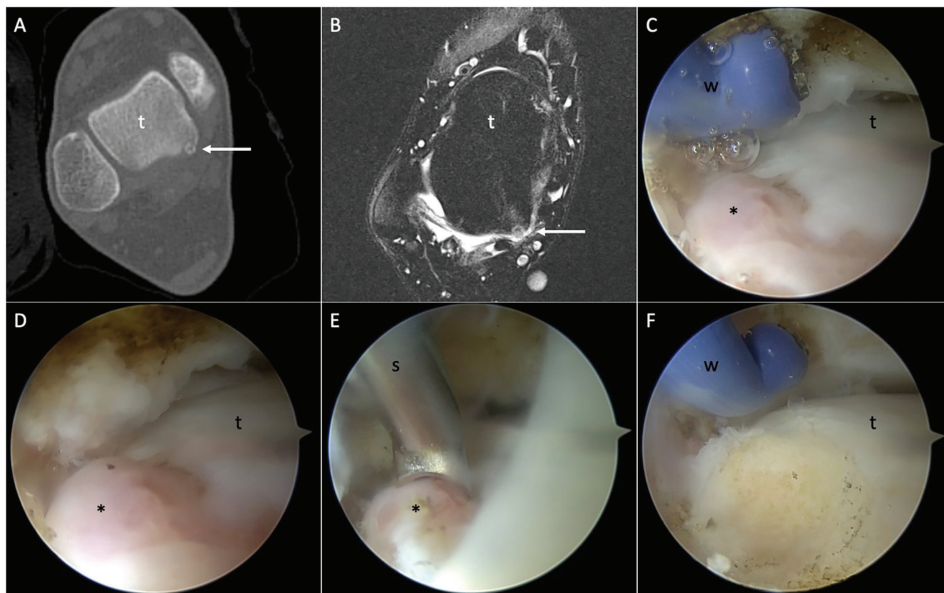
Images depicting a posterior ankle osteoid osteoma case were included in the study. A – an axial computed tomography image of the ankle with an osteoid osteoma (arrow) situated on the posteromedial aspect of the talus (t); B – an axial magnetic resonance image of the ankle with an osteoid osteoma (arrow) situated on the posteromedial aspect of the talus (t) with visible surrounding bone oedema; C – an intraoperative posterior ankle arthroscopy image, with the arthroscope in the posterolateral portal, showing adhesiolysis with a radiofrequency wand (w) through the posteromedial portal in order to reveal osteoid osteoma (asterisk) situated on the posteromedial aspect of the talus (t); D – an intraoperative posterior ankle arthroscopy image, with the arthroscope in the posterolateral portal, after adhesiolysis showing the position of the osteoid osteoma (asterisk) situated on the posteromedial aspect of the talus (t); E – an intraoperative posterior ankle arthroscopy image, with the arthroscope in the posterolateral portal, demonstrating ablation of the osteoid osteoma (asterisk) with an arthroscopic spoon (s); F – an intraoperative posterior ankle arthroscopy image, with the arthroscope in the posterolateral portal, after complete removal of the osteoid osteoma from the talus (t).
